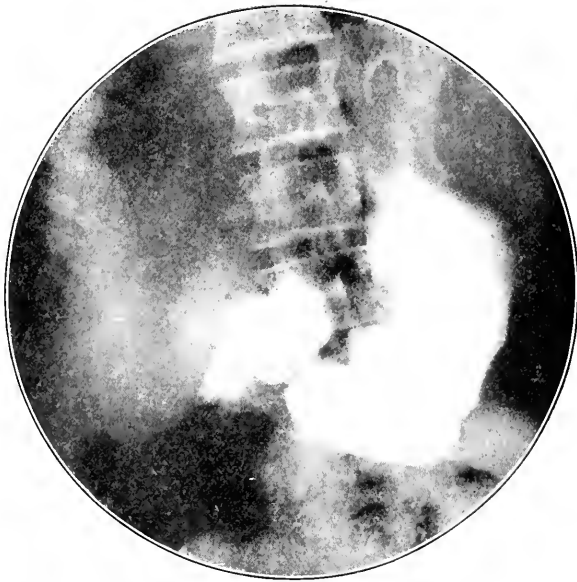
(58949) Two views; First examination May 22, 1914. Roentgen examination negative.
